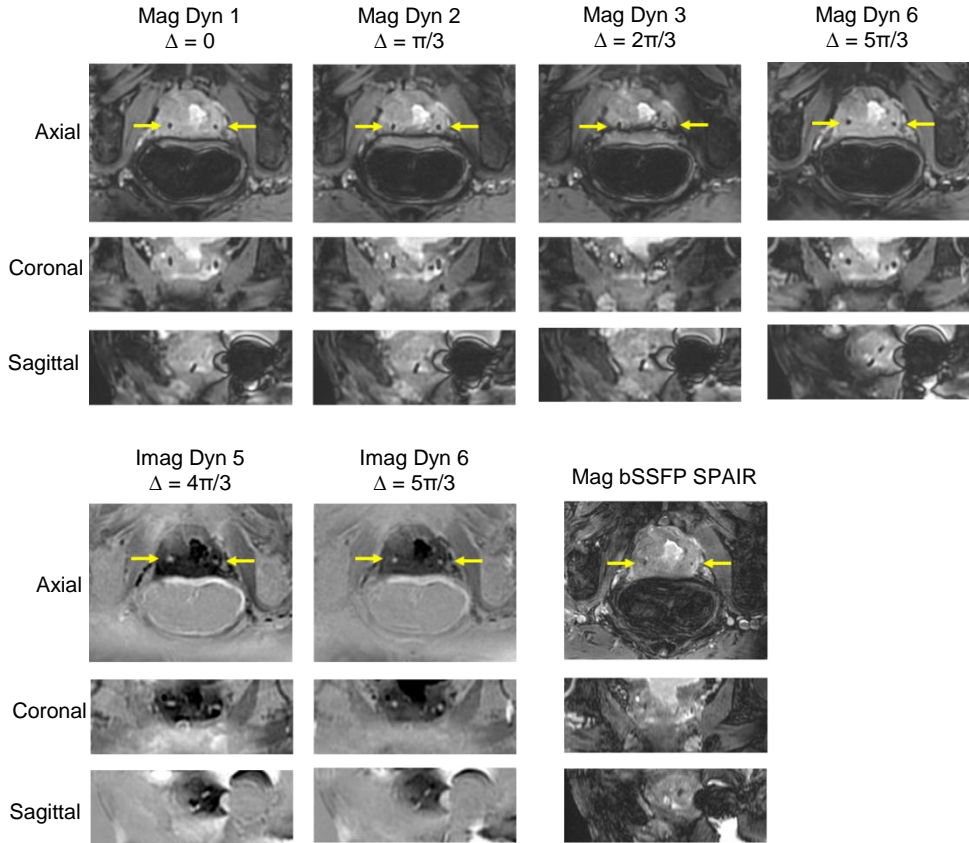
Example of images acquired in a patient with gas in the rectum: the magnitude, real, and imaginary images for axial, coronal, and sagittal planes for few different dynamics. Magnitude image of bSSFP SPAIR used in a standard MRI-only protocol is shown for comparison. Images are shown for 3 orthogonal slices of 3D volumes. Note that the banding artifact close to the rectal wall shifts as results of using phase-cycling. The small yellow arrows indicate the locations of the FMs in the axial images.
